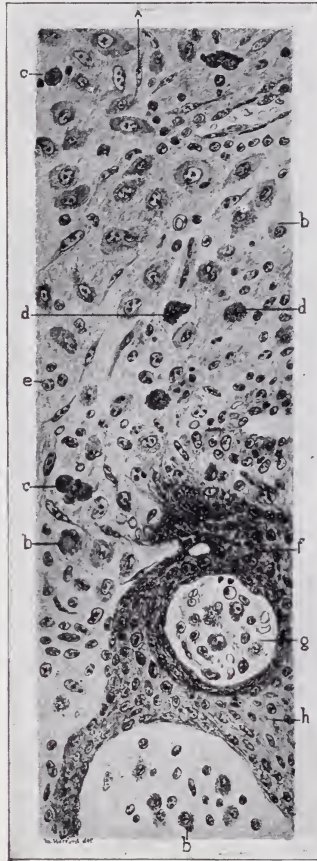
Granulation tissue of periapical infection. *a*, fibroblast; *b*, plasma cell; *c*, hyalin bodies; *d*, eosinophils; *e*, lymphocytes; *f*, leukocytes between epithelial cells; *h*, epithelial cells. (Thoma.)
